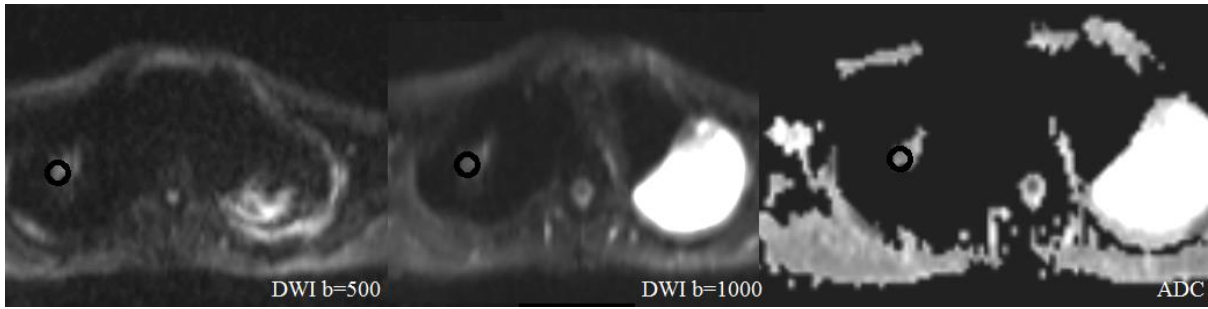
Diffusion weighted images showing no diffusion restriction (isointense on DWI and ADC images). The values obtained from ROI placed within the solid areas shows the following values.
